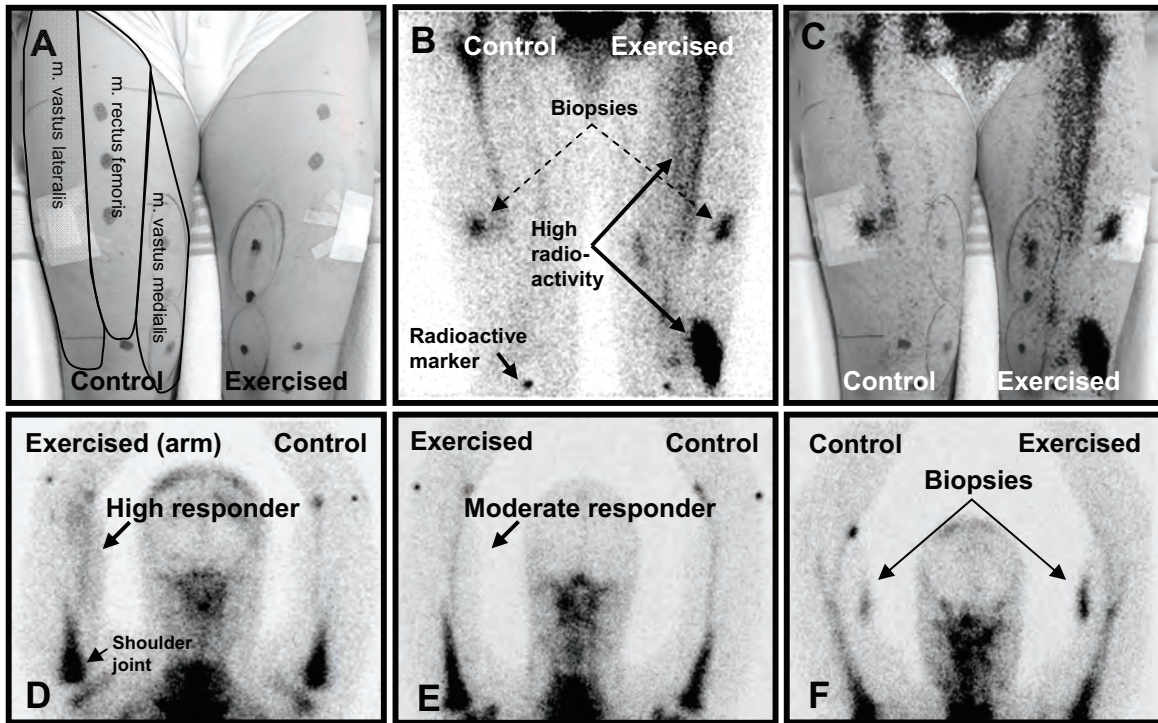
Scintigrams (radionuclide imaging) of legs and arms. The upper row of images shows how scintigrams were superpositioned on photographs (A-C). With this approach we could relate the radioactivity (black pixels) to reference points for each part of m. quadriceps marked on the subjects' thigh with a waterproof pen (A). Image B and D show a high-responder subjects with high radioactivity, i.e., large accumulation of radiolabelled leukocytes in the exercised muscles. Image B: This subject had especially large leukocyte accumulation in m. rectus femoris and the muscle-tendon junction (arrows). Note the difference between D and E (a high- vs. a moderate-responder subject). Image B and F display accumulation of leukocytes due to the biopsy procedure.
